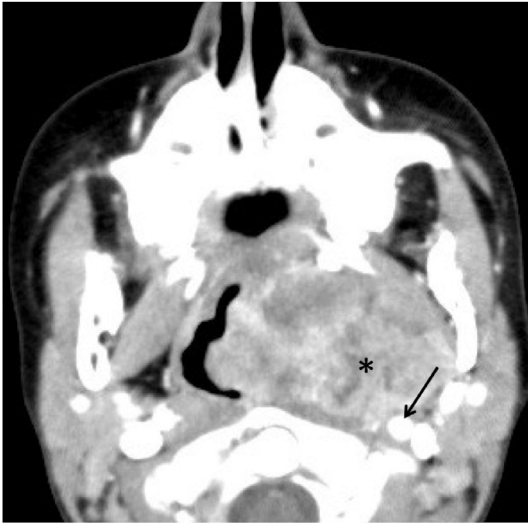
Presurgical Axial CT images. Angiography demonstrating proximity of the tumor (chordoma) (asterisk) with the left extracranial internal carotid artery (arrow).
